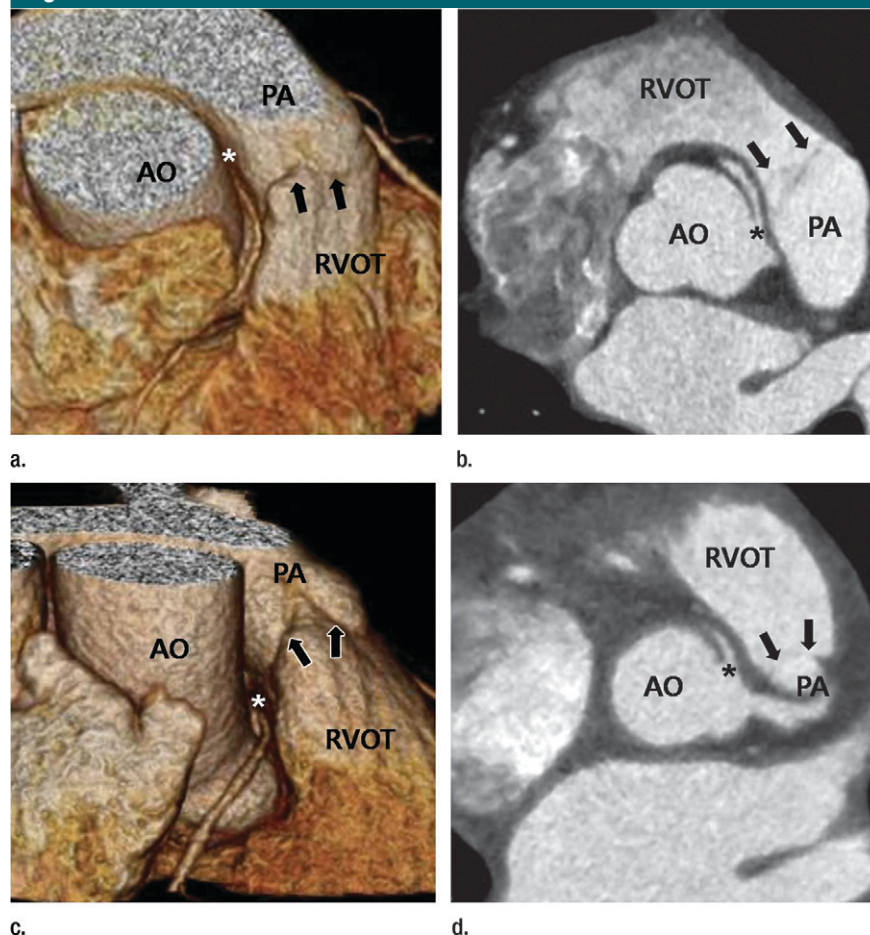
CT images in patients with high and low interarterial courses. (a, b) High interarterial course. (a) Volume-rendered three-dimensional image and (b) aortic valve multiplanar reformatted image in 54-year-old man demonstrate that the anomalous RCA ostium (*, also on c, d) from the left coronary sinus is located between the aorta (AO) and the pulmonary artery (PA) above the pulmonary valve (arrows, also on c, d). (c, d) Low interarterial course. (c) Volume-rendered 3D image and (d) aortic valve MPR image in 61-year-old woman show that the anomalous RCA ostium from the left coronary sinus is located between the aorta and the RVOT below the pulmonary valve.
